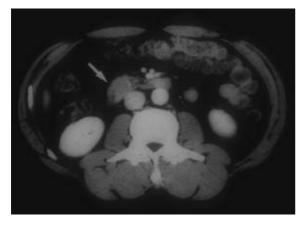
Abnormal computed tomography showing a tumor mass in the pancreatic head.
